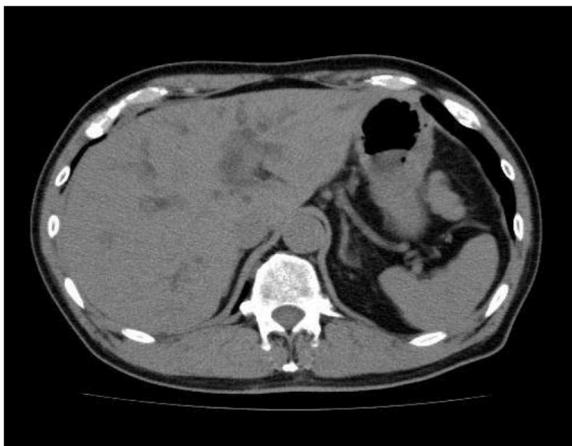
Abdominal computed tomography revealed a dilated intrahepatic biliary tree.
